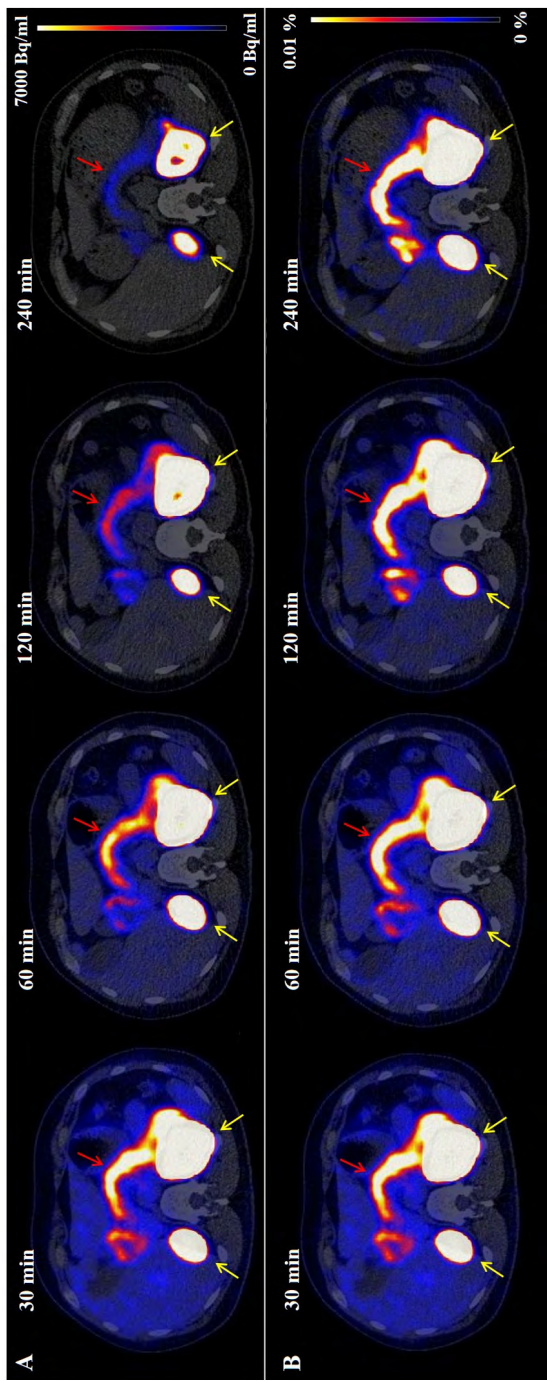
Transversal fused PET/CT images of the abdomen showing the biodistribution of $[^{68}\text{Ga}]\text{Ga-NODAGA-exendin-4}$ at 30, 60, 120 and 240 minutes after injection. (A) Tracer accumulation in Bq/ml showing washout as well as physical decay. (B) Tracer accumulation in % ID/g showing only washout of the tracer. Kidneys are indicated by yellow arrows and pancreas by red arrows.
